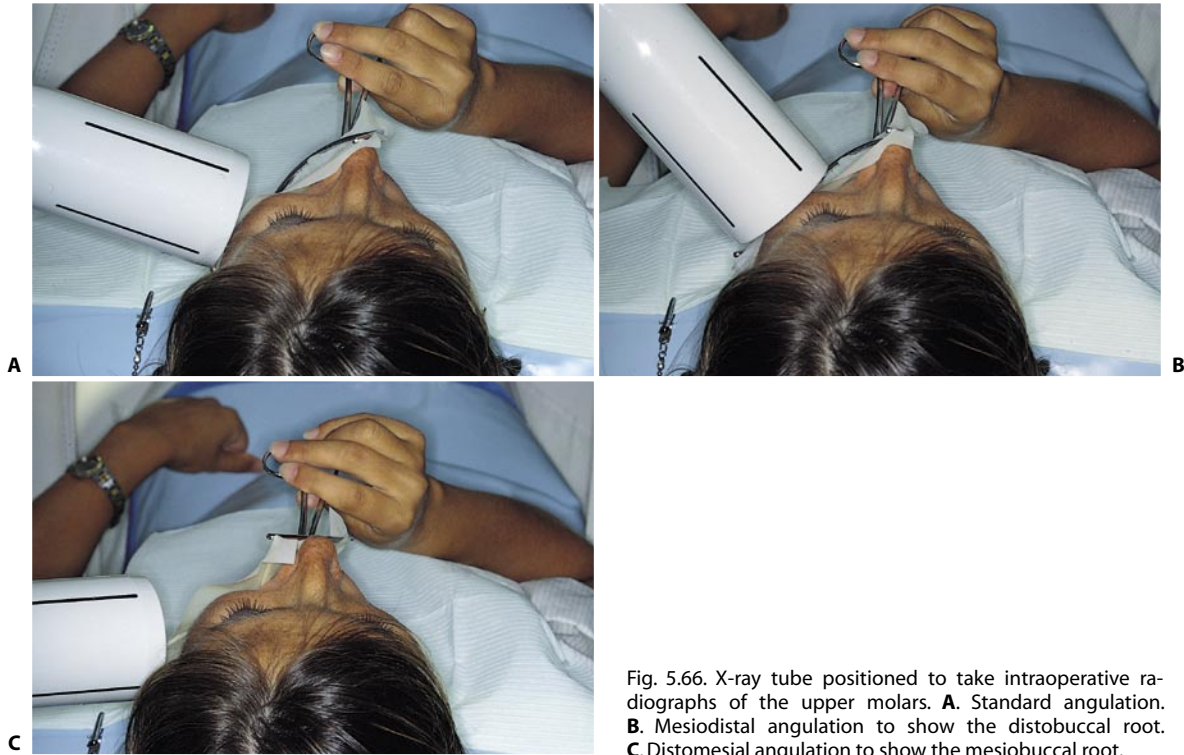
X-ray tube positioned to take intraoperative radiographs of the upper molars. A. Standard angulation. B. Mesiodistal angulation to show the distobuccal root. C. Distomesial angulation to show the mesiobuccal root.
